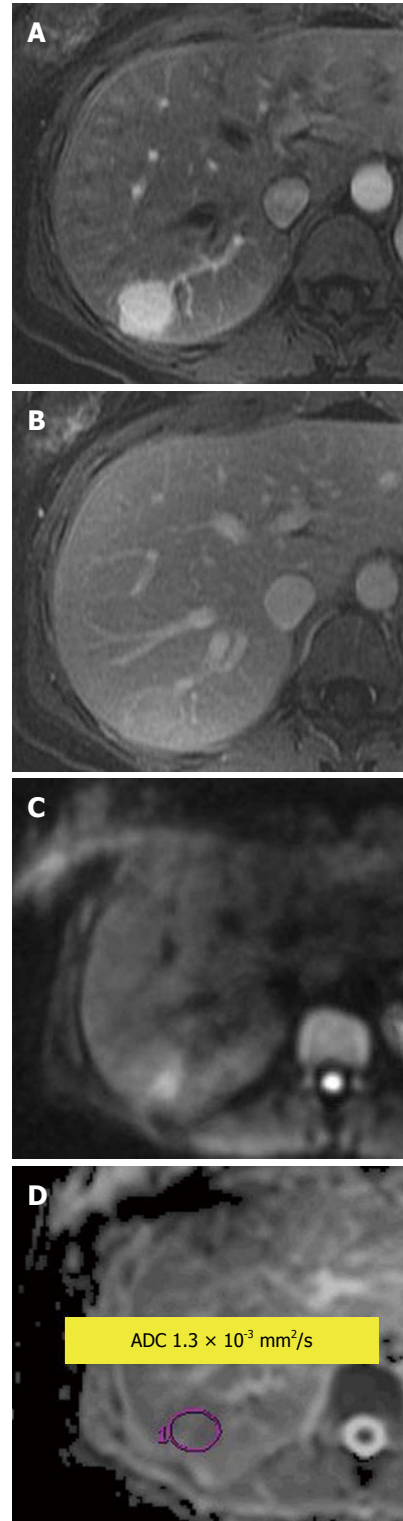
Focal nodular hyperplasia. A: Enhanced arterial phase; B: Venous phase T1-weighted gradient recalled-echo; C: Diffusion-weighted image; D: Apparent diffusion coefficient map (ADC). An arterial enhancing lesion which becomes isointense to slightly hyperintense to liver on venous phase and shows impeded diffusion with ADC of $1.3 \times 10^{-3} \text{ mm}^2/\text{s}$.
